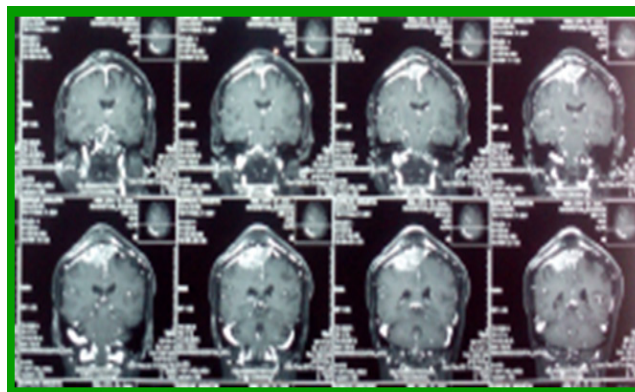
Patient's MRI showing heterogenous intracranial mass
